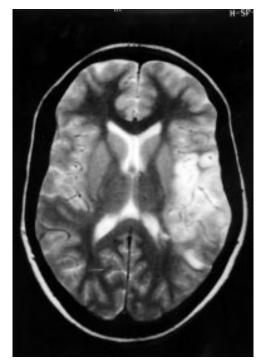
Axial image from MRI on day 10 after admission.
